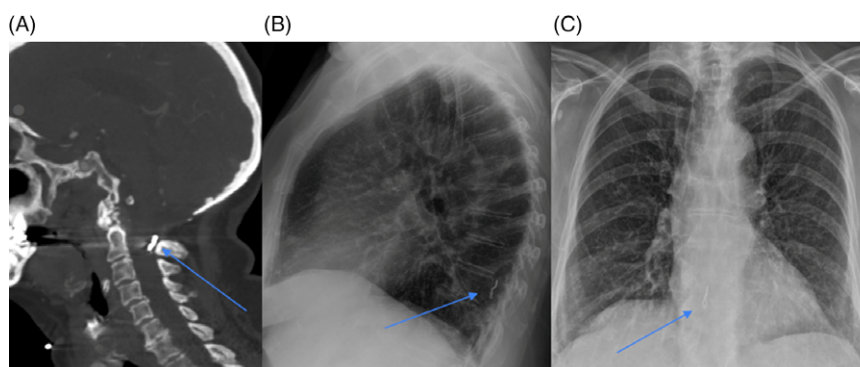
(A) CTA Sagittal reconstruction shows the Clip posterior to cord at C2 (arrow); (B) Chest X-ray lateral view & (C) frontal view shows the Clip anterior to cord at lower thoracic spine (lateral and AP views – arrows).
